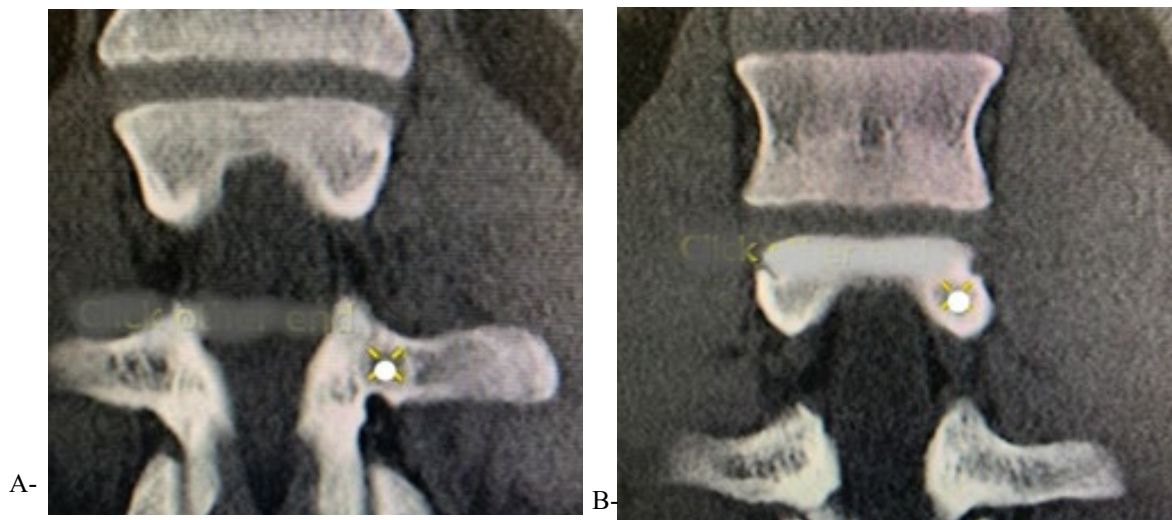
A-B: sagittal CT cuts with the correct points of registration at the entry point as shown in fig. A. and at the pedicle-vertebral body junction as shown in fig. B. (please note the cancellous bone and the cortical bone shell surrounding).
